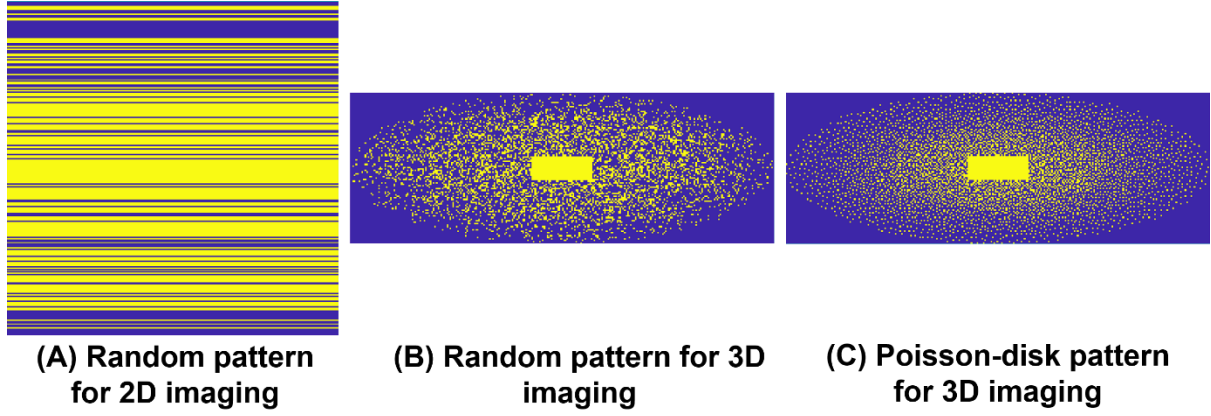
Typical MRI sampling patterns. (A) A random sampling pattern for 2D Cartesian acquisitions (k_x - k_y). (B) A random sampling pattern for 3D Cartesian acquisitions (k_y - k_z). (c) A pseudo-random Poisson-disk sampling pattern for 3D Cartesian acquisitions (k_y - k_z).
